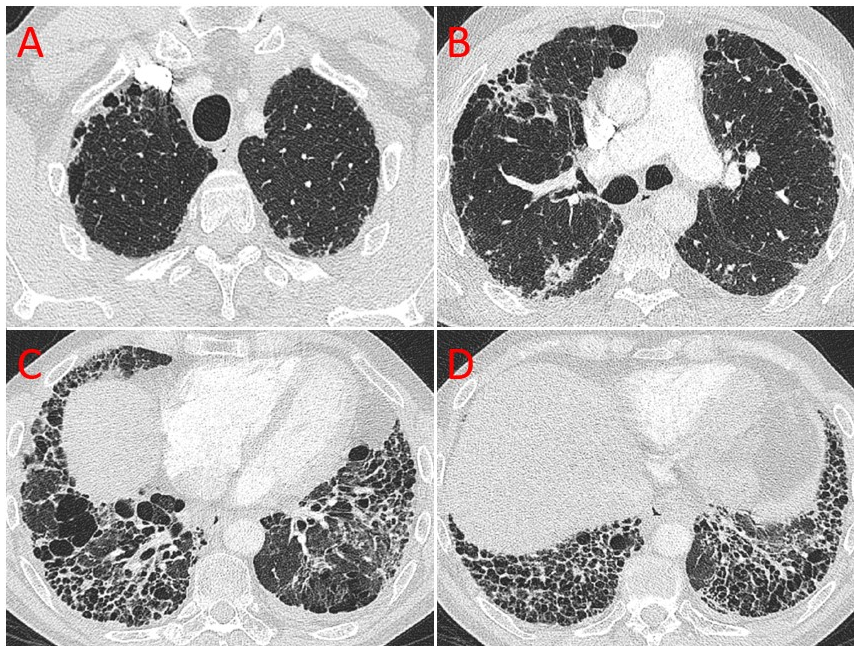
High resolution CT dicom's from a patient with Idiopathic pulmonary fibrosis from the ILD-PH cohort.
